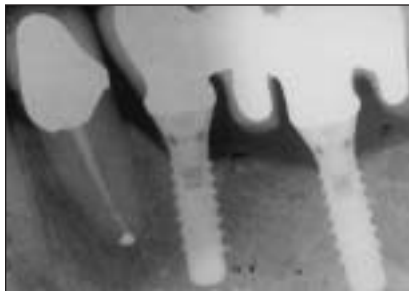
Juxtagingival radiograph of an FP prosthesis.
